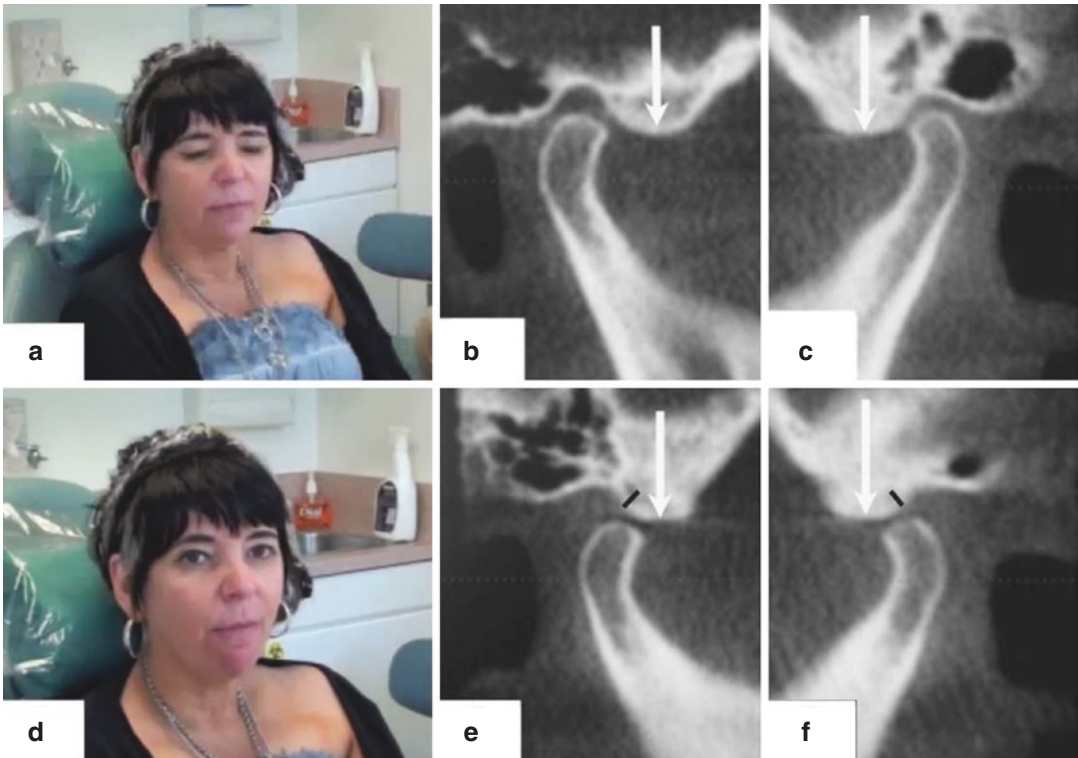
A blepharospasm patient (Case 5) before (a) and (d) after insertion of an orthotic into her oral cavity. CT scan images of the right and left (b, c) temporomandibular joints in the patient before treatment. At the time of examination, demonstrating the mandibular condyle and articular eminence relationship, with the patient engaging her normal bite. There is flattening of the anterior surface of both condyles indicating the early stage of osteoarthritic changes (a, b). Note the narrow joint space on the left TMJ (b). The mal-relationship is evident in the left joint, the left condyle being positioned posteriorly and superiorly in the infratemporal fossa. This causes compression of the retrodiscal tissue where the AT nerve is situated. The condyles are repositioned
